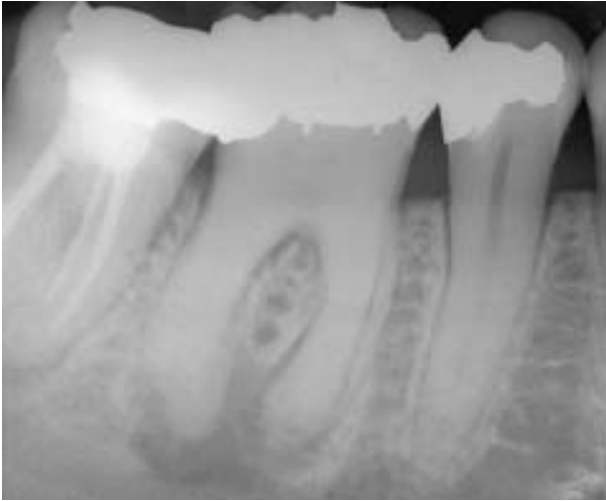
Tooth 46 – Periapical radiograph of the only tooth in the study that did not have caries, cracks or marginal breakdown evident when the existing restoration was removed. However, the restoration had been replaced only eight months prior to being examined as part of the current study.
